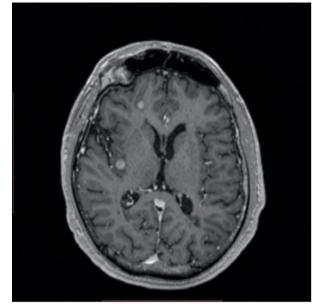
Multiple contrast-enhancing lesions-ontrast enhanced T1 MRI, May 2017
